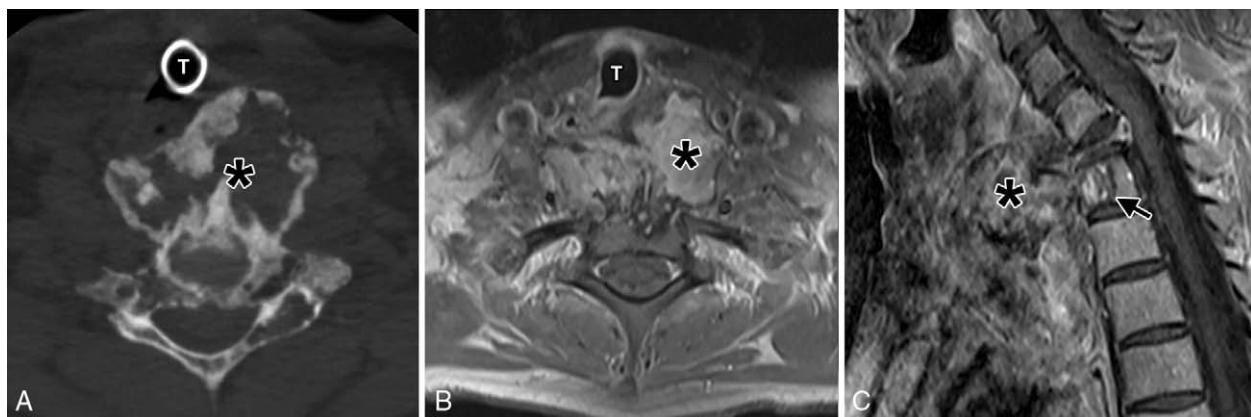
Follow-up imaging after treatment with subcutaneous denosumab. (A) Axial CT image shows marked decrease in size and increased mineralization of the GCT (asterisk). The shrunken tumor with well-defined corticated borders no longer compresses and displaces trachea. A tracheostomy tube (T) is in place; however, there is no compression or displacement of the trachea. (B) Axial postcontrast MRI at the level of T1 shows decrease in size of the mass (*) with mineralization resulting in decreased signal peripherally T1WI. A tracheostomy tube (T) is in place. (C) Sagittal MRI shows resolution of the epidural disease, but persistent spinal canal narrowing due to C7 retropulsion. The prevertebral soft tissue mass (*) has decreased enhancement compared with the pretherapy MRI (Figure 1). CT indicates computed tomography; GCT, giant cell tumor; MRI, magnetic resonance imaging.
